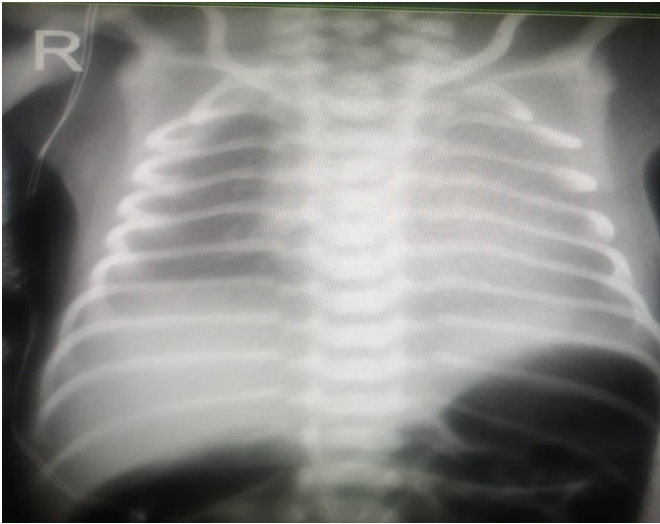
Typical X-ray appearance of neonatal respiratory distress syndrome (NRDS).
